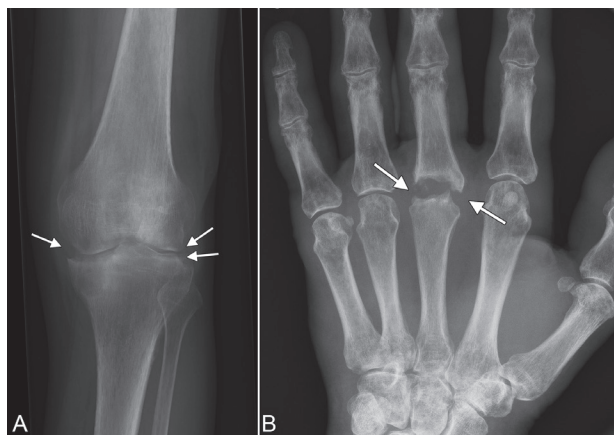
(A) X-ray of the left knee joint showing reduction in height of the cartilage laterally and medially (arrows), fissures on the tibial articular surface and general osteopaenia. (B) X-ray of the left hand showing that adjacent edges of the articular surfaces in the 3<sup>rd</sup> metacarpophalangeal joint (arrows) are irregular and sclerotic, corresponding to status post-septic arthritis. (From ref 18 with permission from Acta Derm Venereol).
